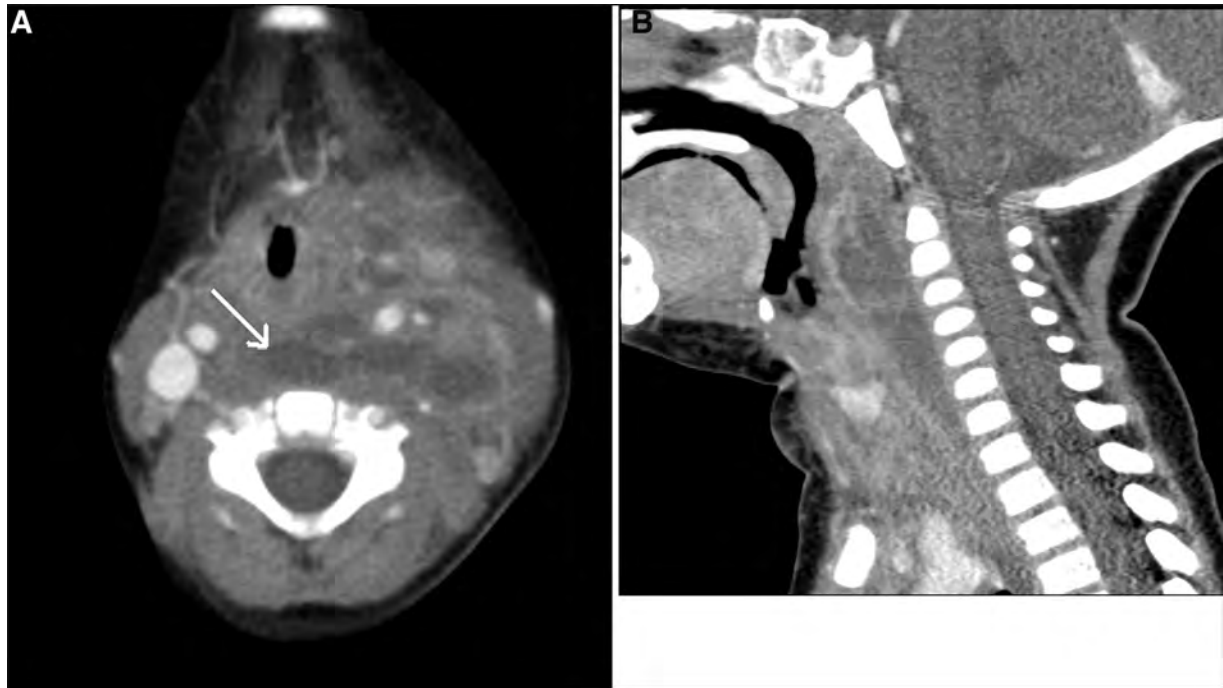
Computed tomography scans with contrast showing retropharyngeal abscess. Department of Radiology, Miami Children's Hospital, FL.
